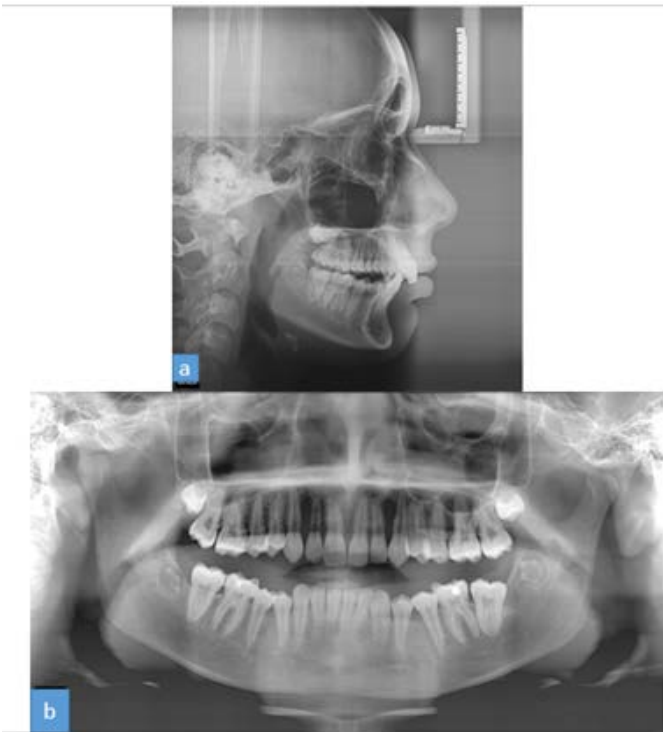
After Twin Block phase (a) Lateral Cephalogram (b) Orthopantomogram.
